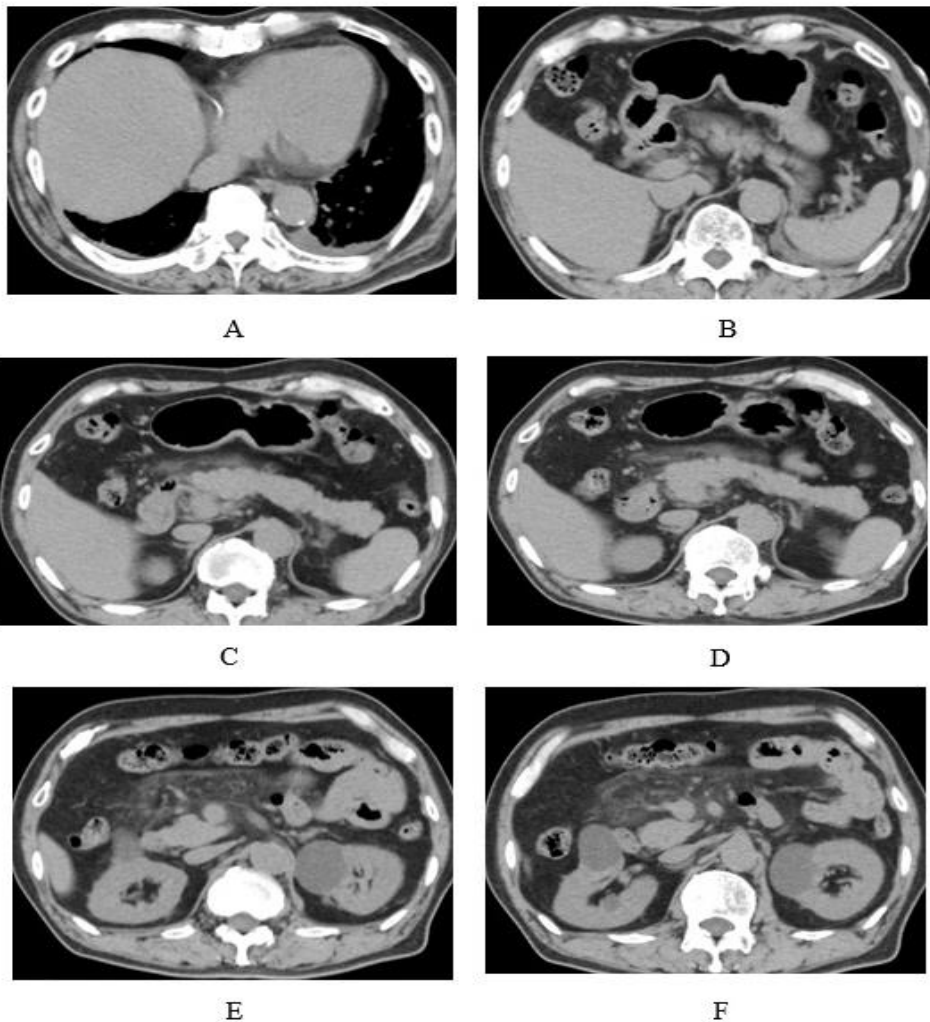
Fat dirty sign is demonstrated in fat tissue anterior to pancreas (B, C, D) and behind transverse colon (E, F) is visualized on non-enhanced abdomen CT. Note small left pleural effusion (A).
